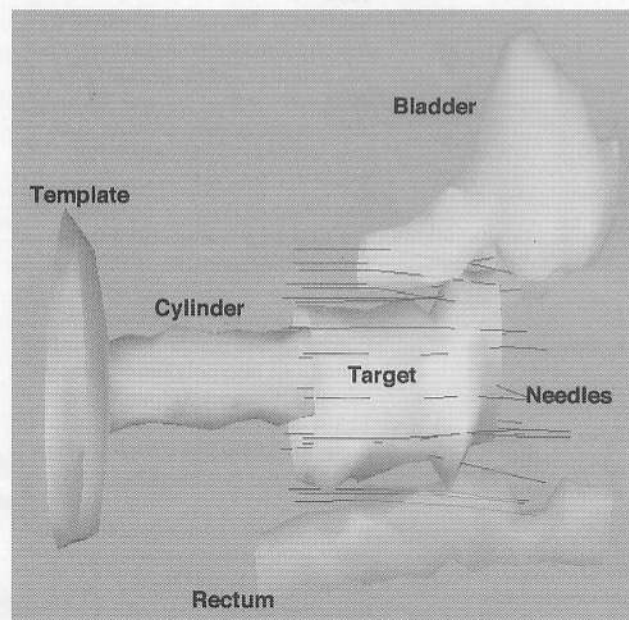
Reconstructed objects from a CT scan for the case of an Ir-192 vaginal template implant. All needles are shown from the tip of their insertion to the most inferior position (left) to which they might be loaded with radioisotopes in order to treat the target volume. The template was used to guide needle insertion.
